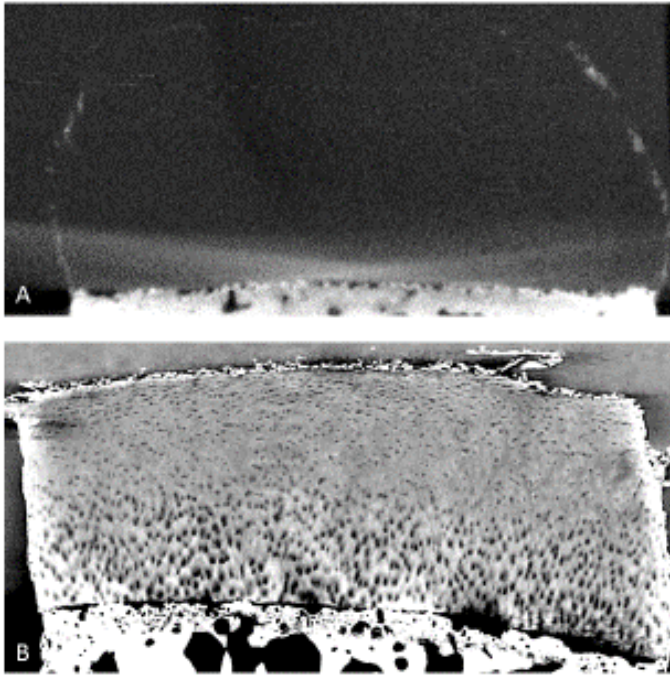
Two sagittal slices from a healthy cartilage sample with the same effective pixel size of 6 μm but with different X-ray sources. A) Rotating anode X-ray source; the edges of the sample are visible, but no other detail within the tissues are depicted B) Synchrotron radiation source (ID17); the cartilage structure (chondrons, interterritorial matrix) is well shown due to the additional phase signal.
